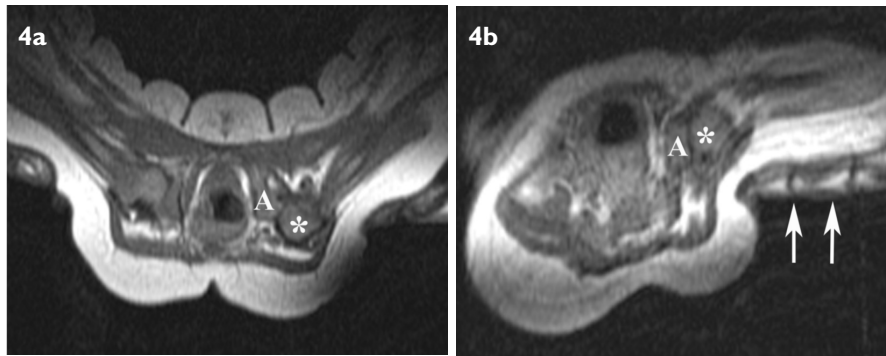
A two-month-old infant diagnosed at the age of four weeks with left hip dysplasia. (a & b) Axial fast spin-echo T1-W dynamic motion MR images performed during the Ortolani reduction manoeuvre show a partial reduction of the posteriorly-dislocated femoral head (*). Note the fingers (arrows) of the physician performing pressure in an attempt to reposition the femoral head within the acetabulum (A). A stable reduction could not be achieved and this patient had to proceed to open surgical reduction.
